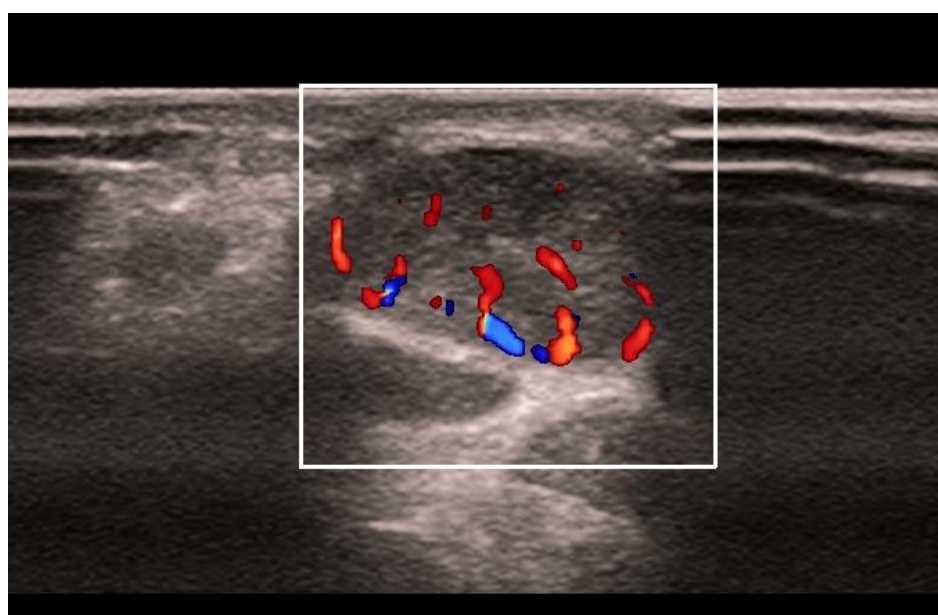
Doppler Ultrasonography Showing a Good Vascularization of the Mass.
